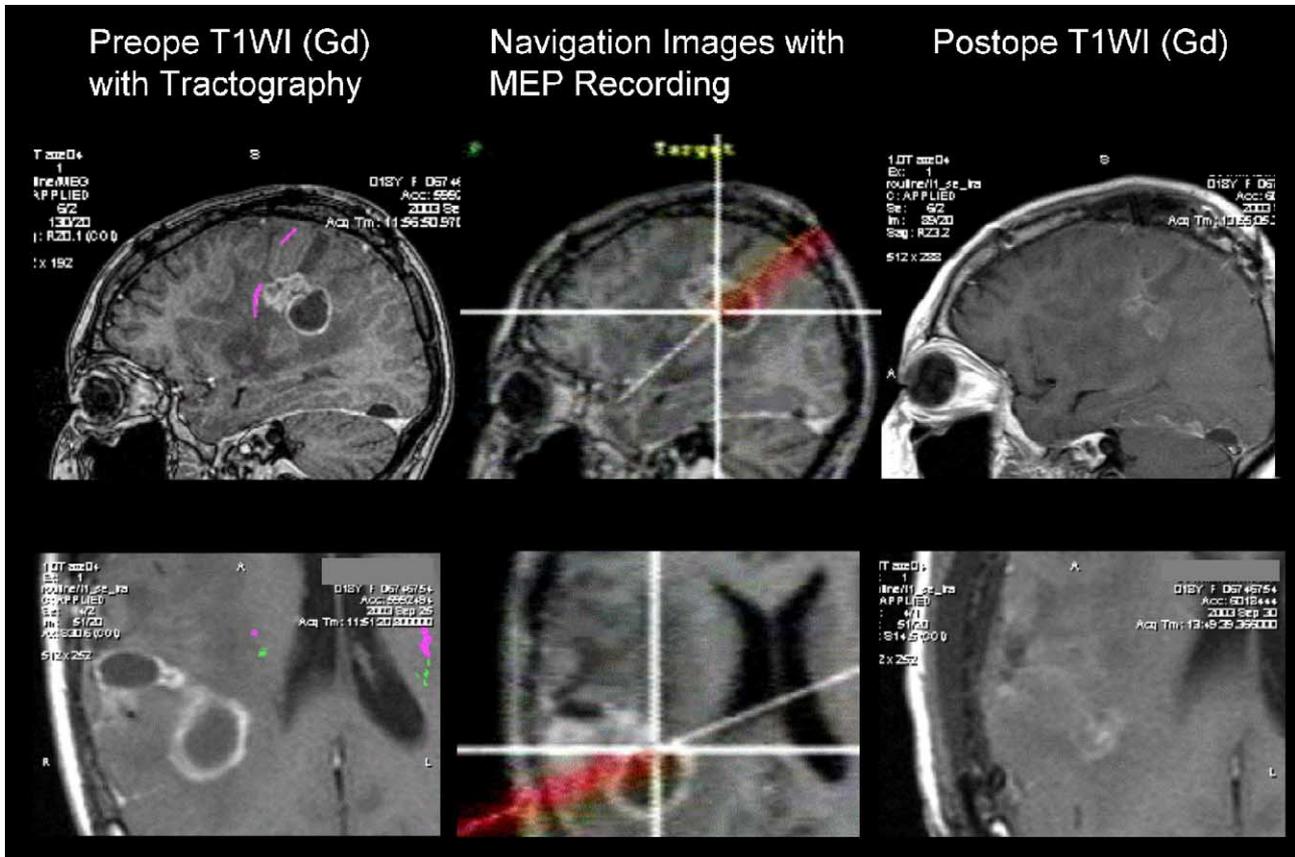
(Patient 2) MR images. Left row: preoperative sagittal and axial Gd-enhanced MR images with tractograph traces. Note the ring-enhanced mass with a cystic component in the right parietal lobe. The purple and green lines represent the pyramidal and sensory tracts, respectively. Both appear to be far anterior and medial to the cystic tumor component. Middle row: images obtained intraoperatively with the EVANS neuronavigation system. At the target, the intersection of the white lines, subcortical electrical stimulation elicited a positive response. Compared to the fiber-tracking images, its location is much posterior and lateral to the depicted pyramidal tract. This portion, considered to be the wall of the cystic component, was not touched. Right row: postoperative MRI confirming complete resection of the tumor. This patient experienced no neurological sequelae.
